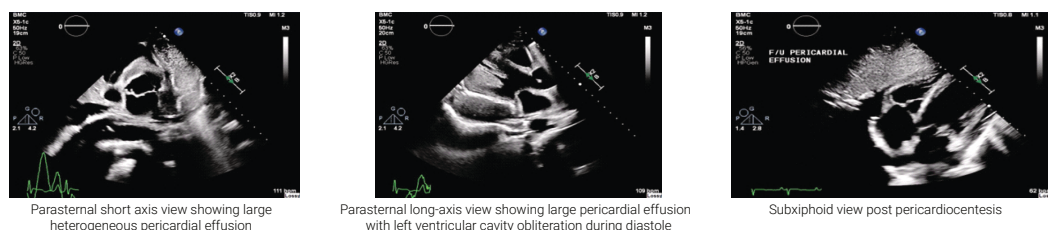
Transthoracic echocardiography demonstrating a large heterogeneous pericardial effusion with diastolic left ventricular compression on parasternal views, and reduction in effusion following pericardiocentesis on subxiphoid imaging
